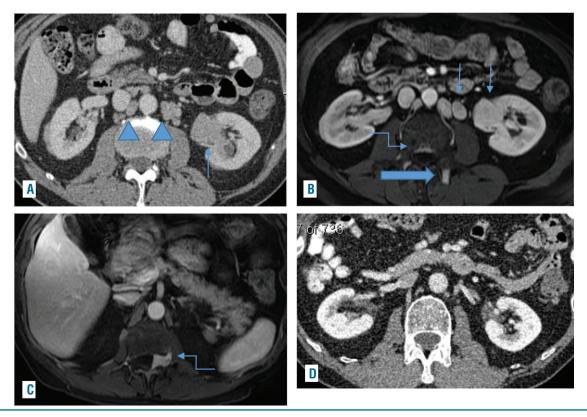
Imaging findings before and after treatment. A. Axial image of contrast enhanced CT at the level of right renal vein reveals enlarged periaortic nodes (arrowheads) and soft tissue in left renal pelvis (thin arrow). B. Axial image of contrast enhanced MR at the level right renal vein reveals enlarged periaortic nodes and soft tissue in left renal pelvis (thin arrow). Osseous (thick arrow) and epidural lesions (zigzag arrow) are also noted. C. Axial contrast enhanced MR image at the level of L1-L2 level reveals enhancing mass extending into left neural foramen at that level with mass effect on spinal cord (zigzag arrow). Many other osseous lesions were noted on MR spine (not shown) D. Axial image of contrast enhanced CT at the level of right renal vein reveals resolved periaortic lymphadenopathy and soft tissue in left renal pelvis dated 2 years after anti-IL-6 therapy.
